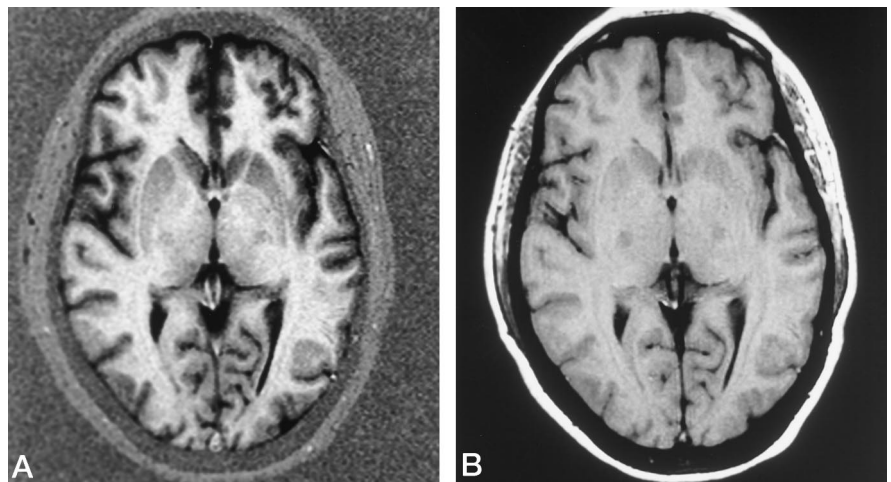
The contrast between gray matter and white matter as evidenced by the margins of the caudate, internal capsule, and basal ganglia is significantly improved on the IR-EPI sequence (A) as compared with the conventional T1-weighted spin-echo image (B).
